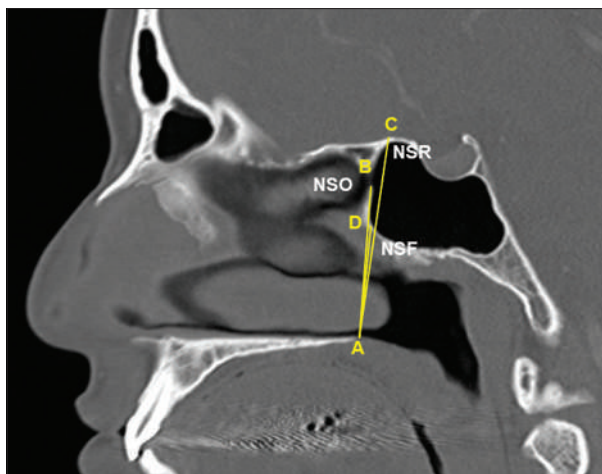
Sagittal CT image showing AB, AC, AD; distance from the posterior end of the palatum durum to the sphenoid orificium, roof and floor of anterior wall of sphenoid sinus, respectively. CT: Computed tomography
